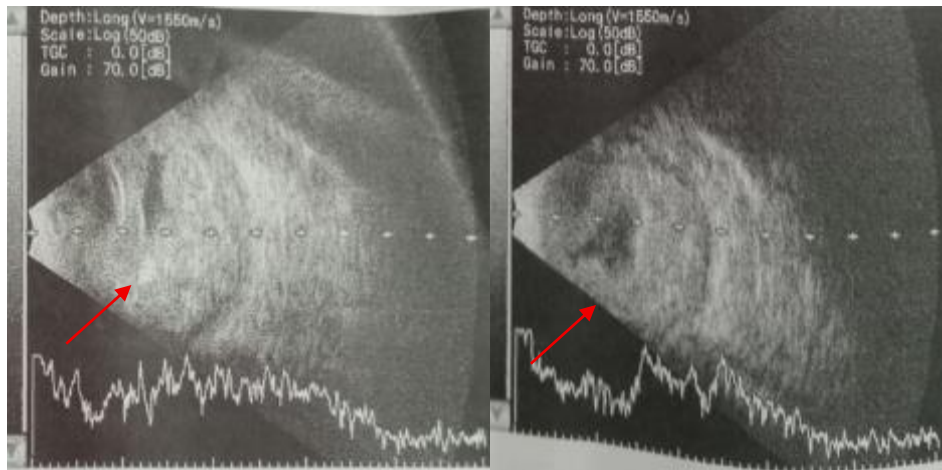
B-scan ultrasound – intraocular solid mass indicated by a red arrow
